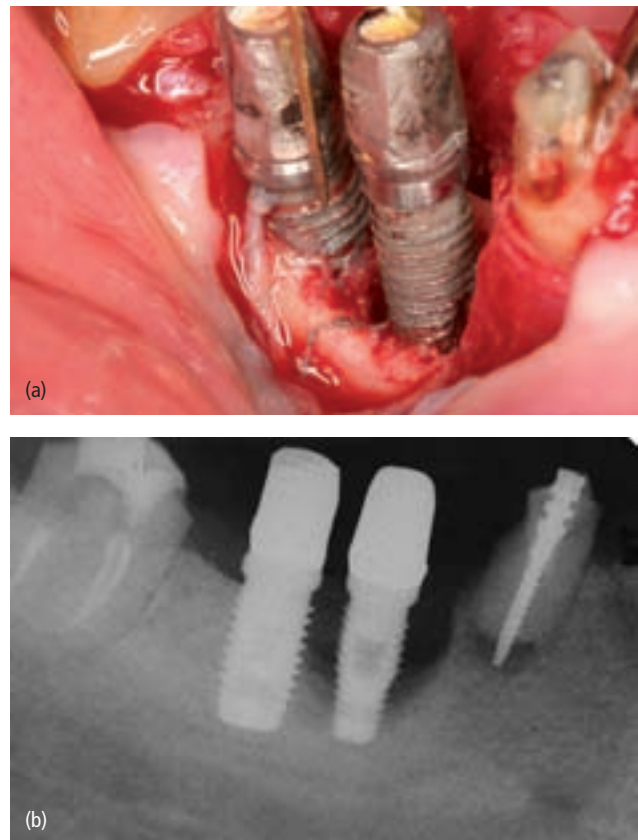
(a) Clinical photograph of hopeless implant no. 29, bone loss around implant no. 30 and hopelessly involved tooth no. 28; (b) radiograph of implants seen in (a).
